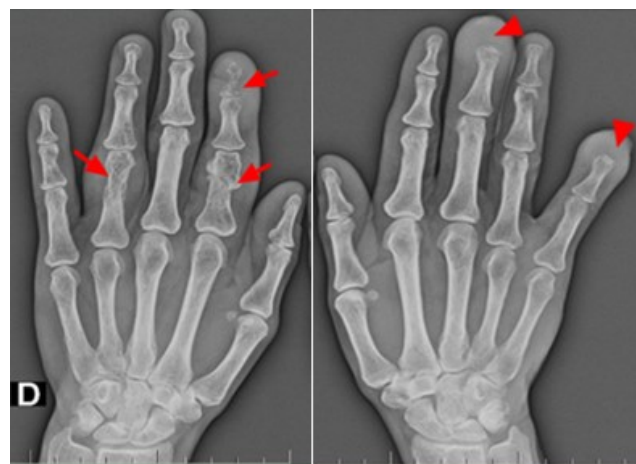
X-ray film exhibiting multiple cystic areas of the digital bones (arrow), soft tissue swelling and missed phalanges (arrowhead).
